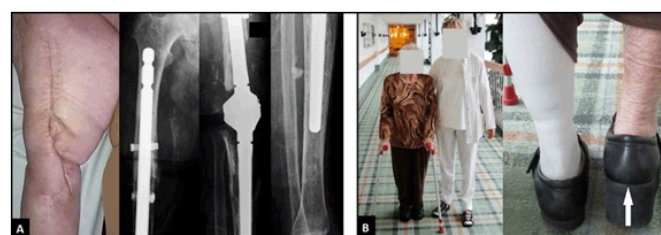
(A) Clinical photograph and PA and lateral radiographs showing uncomplicated wound healing and correct positioning of the new arthrodesis nail, (B) Clinical photographs demonstrating mobilization of the patient with a rise of her right shoe of eight cm (arrow).
